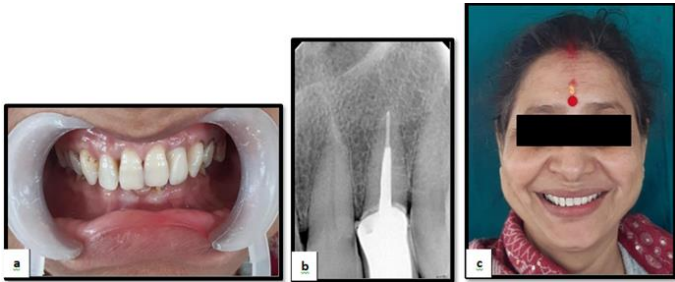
(a) Buccal view of the Richmond crown with respect to 22; (b) Radiograph of cemented Richmond crown; (c) Post-operative profile image
